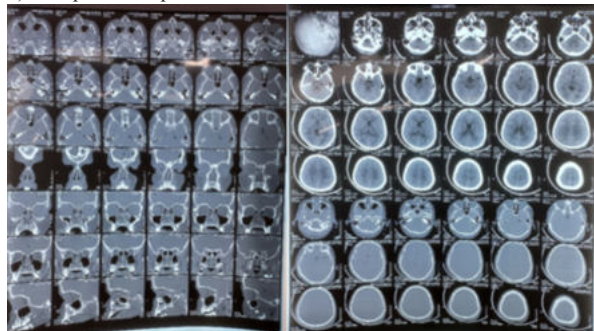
Plain axial CT scan of brain and orbit Figure 8: Plain axial CT scan of brain and orbit
